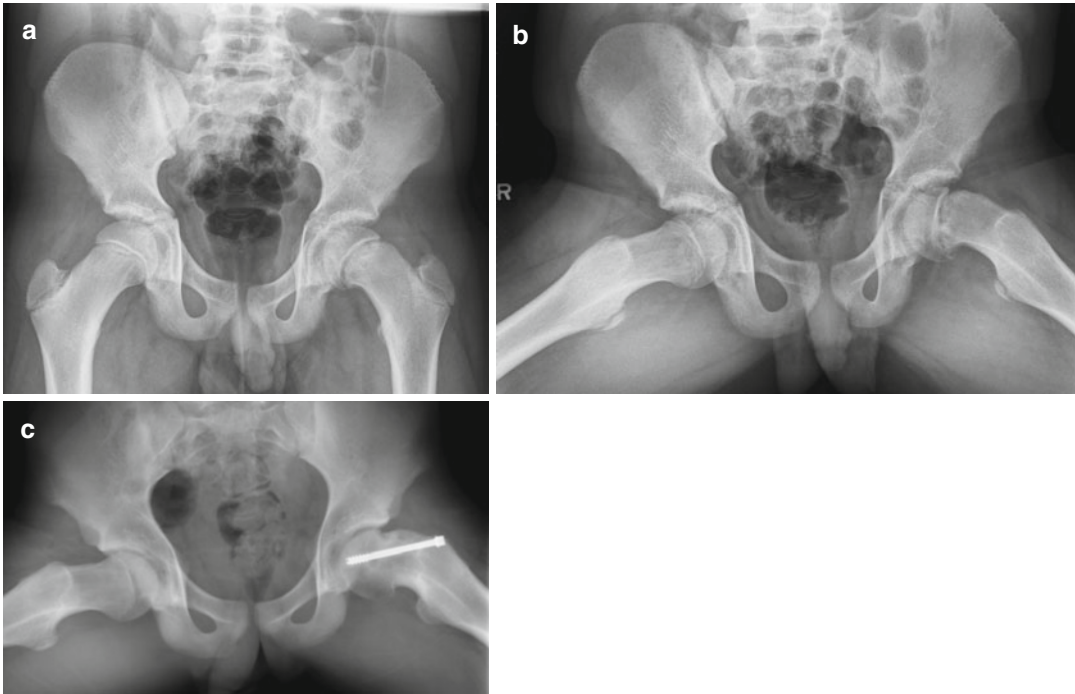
Femoroacetabular impingement secondary to SCFE. The initial presenting radiographs demonstrating a mild SCFE on the AP (a) and frog-lateral (b) radiographs.
